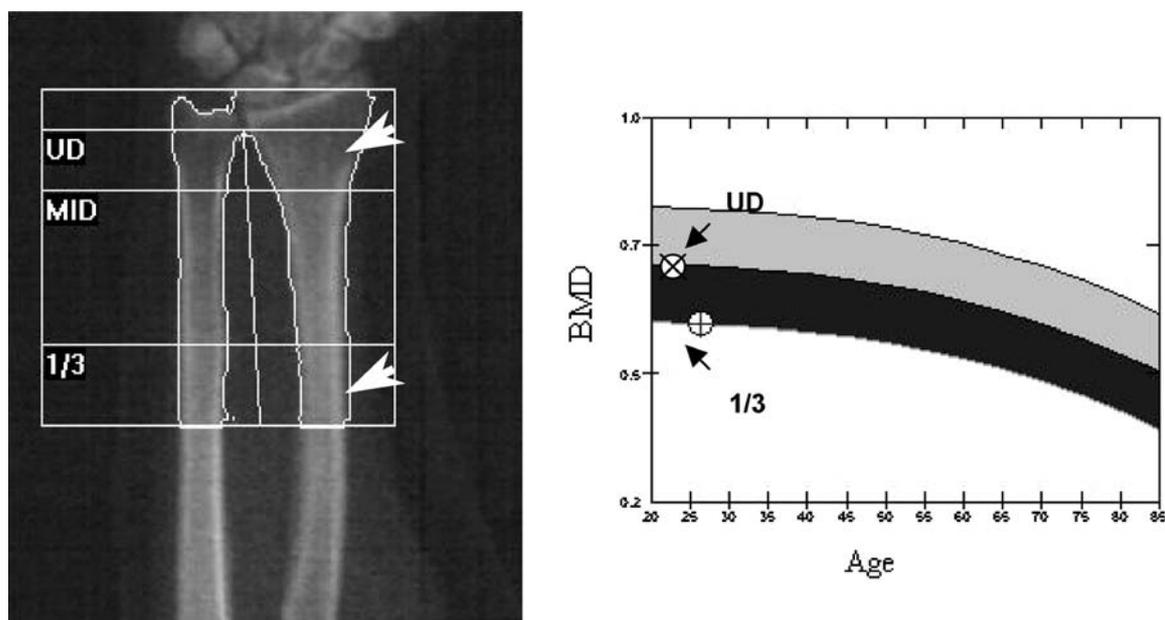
Selective reduction in cortical bone mineral density in TS. The radiograph on the left is a DXA image used to measure BMD at the wrist. The ultradistal radius (UD) is largely trabecular bone, and the proximal 1/3 radius is predominantly cortical. The score for the distal, trabecular radius is normal, but the cortical region mineral content is approximately 2 SDs below normal. Adapted from ref [94].
